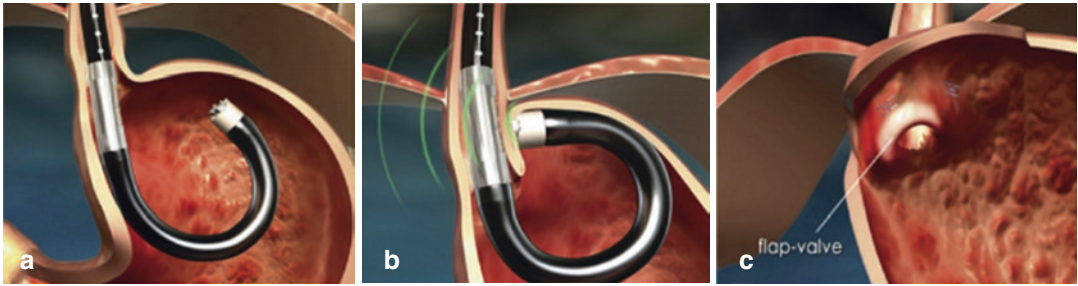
Transoral incisionless fundoplication with MUSE™ endostapler. (a) MUSE™ endoscopic stapler. (b) Ultrasound guidance, device in retroflexion, and ready
